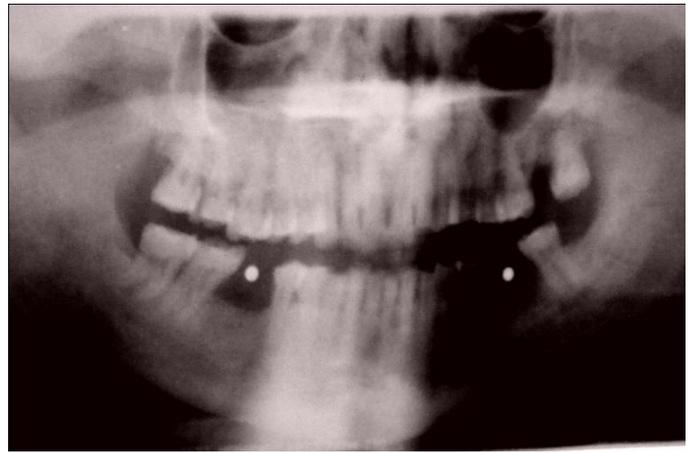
A radiographic splint using two metal bearings to identify location of implant
